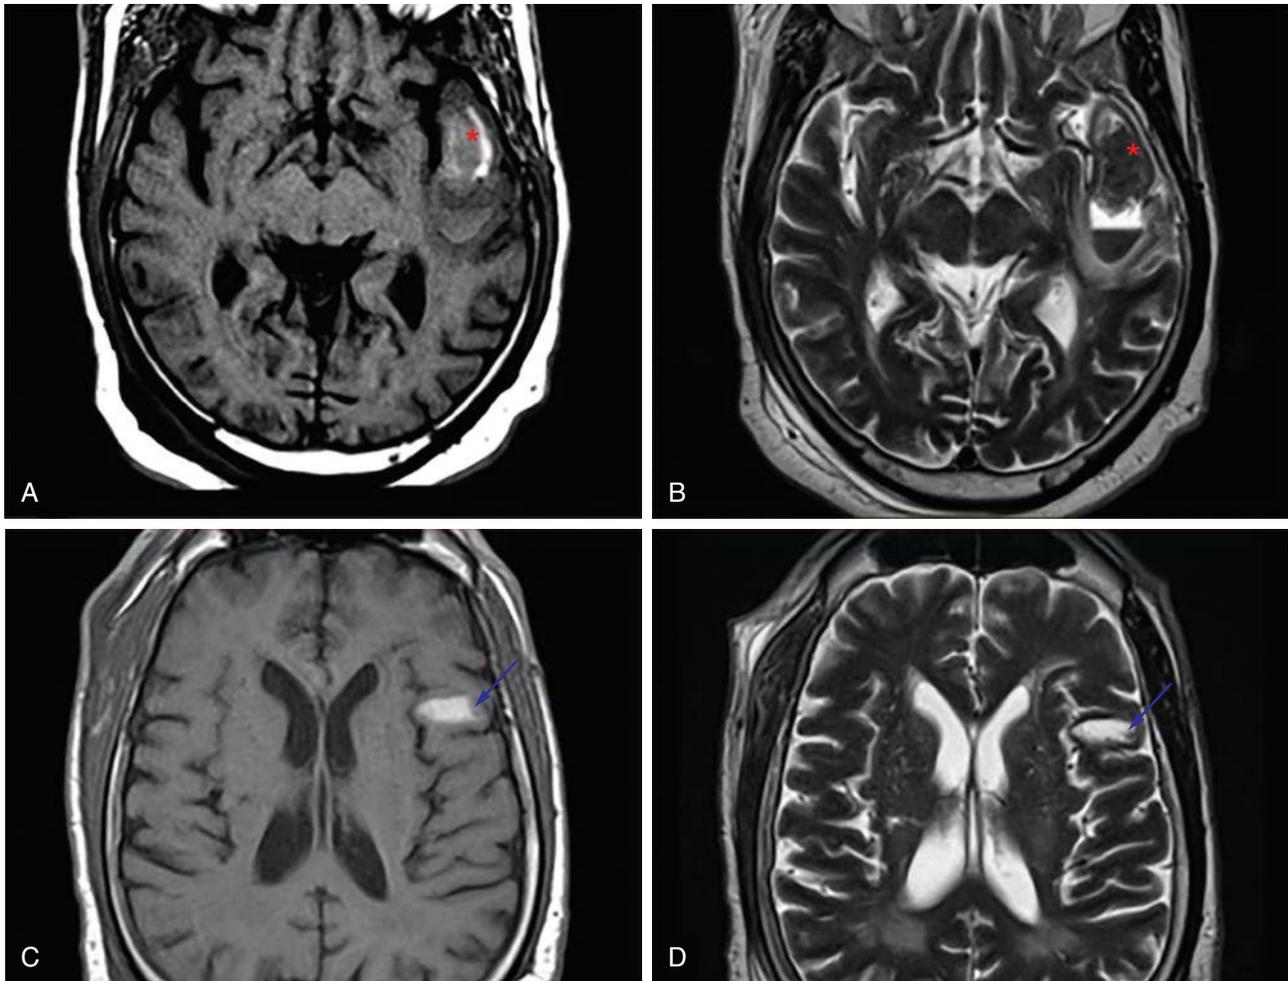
Evolution of intracranial hemorrhage on MRI. A and B, Early subacute blood appears hyperintense on T1-weighted images (A) and hypointense on T2-weighted images (B) (red asterisks). C and D, Late subacute blood appears hyperintense on both T1- and T2-weighted images (blue arrows).
